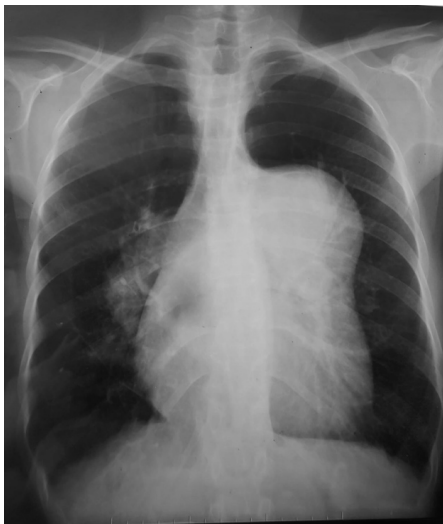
Chest X-ray showing cardiomegaly with the prominent middle left arch and double outline of the lower right arch.
